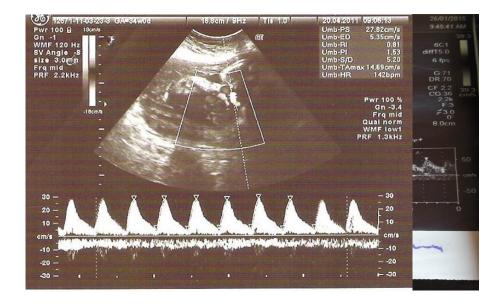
shows normal Color Doppler of the umbilical artery waveform at 36 Wks.
